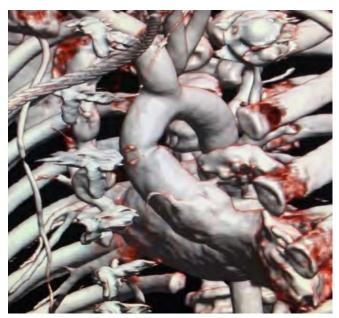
Postoperative CT scan. Post-surgical control at 5 months, observing adequate continuity of the aortic arch.
